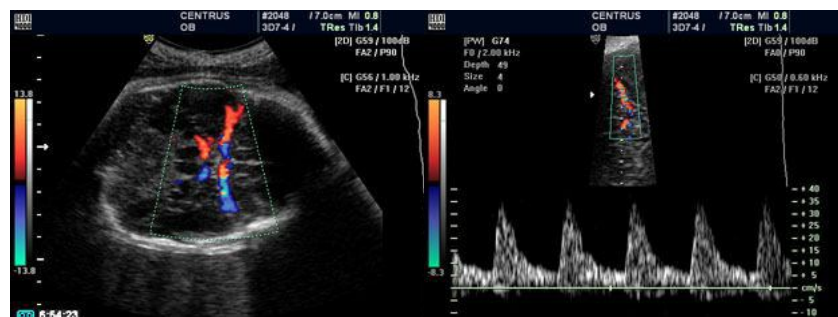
Transverse view of the fetal head with color Doppler showing the circle of Willis (left). Flow velocity waveforms from the middle cerebral artery at 32 weeks of gestation (right).
